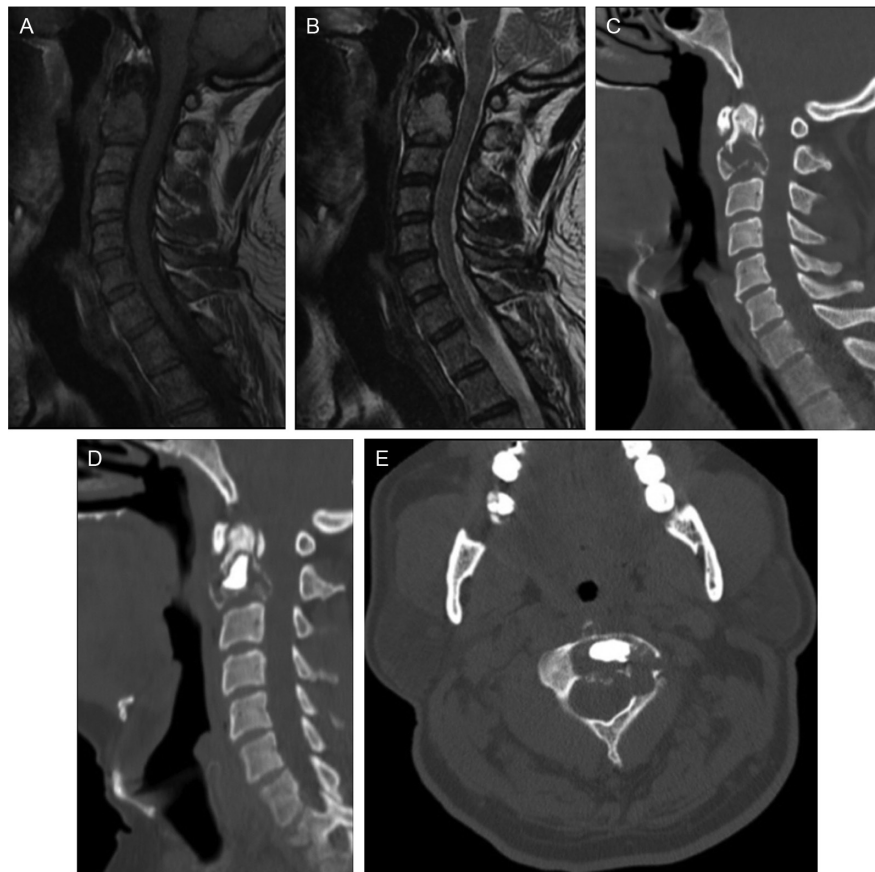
A-E. Preoperative and postoperative images of a case of C2 plasmocytoma. (A) Preoperative T2-weighted sagittal MRI showing the tumor. (B) Preoperative cervical spine CT showing osteolytic changes of C2 vertebra. (C) Postoperative cervical spine CT showing cement inside of C2 body and odontoid process. MRI, magnetic resonance imaging; CT, computed tomography.
